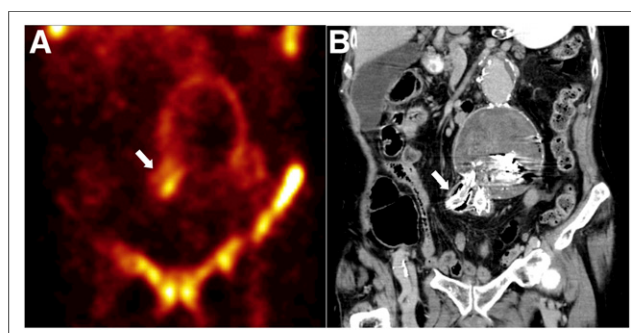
Coronal ^{99m}Tc -labeled white blood cell scintigraphy SPECT (A) and CT (B) images of abdomen, with arrows indicating deployed vascular stents in right common iliac artery.
